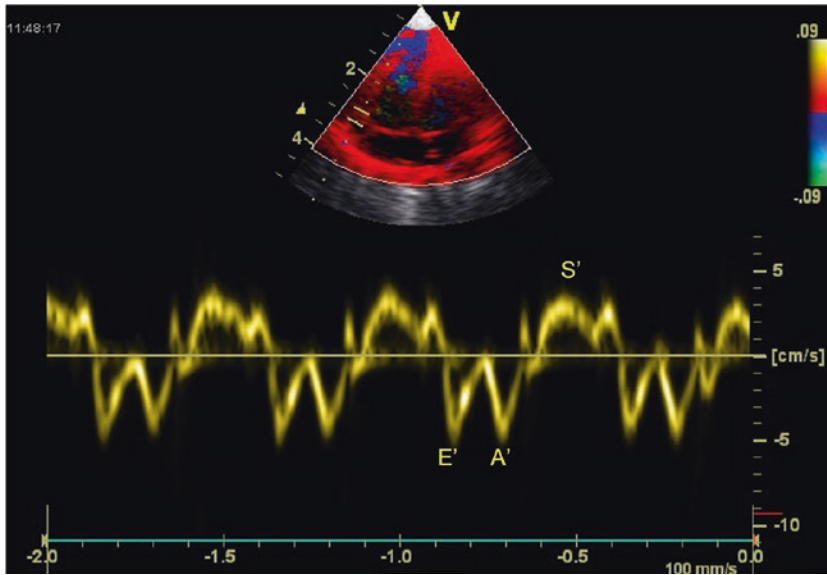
Tissue Doppler Imaging (TDI) tracing obtained at the septal annulus showing S' (systolic velocity) wave, E' (early diastolic velocity) wave, and A' (late diastolic velocity related to atrial contraction) wave
